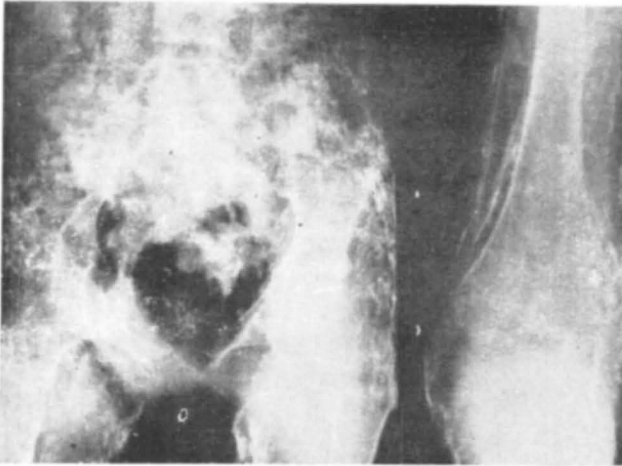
X-rays of pelvis and knee showing widespread calcification of soft tissue of upper thighs and knee.
